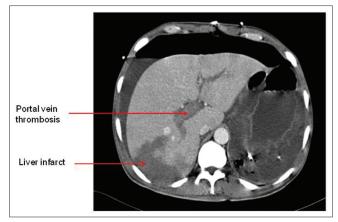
Computed tomography scan of patient showing portal vein thrombosis and infarction of liver
